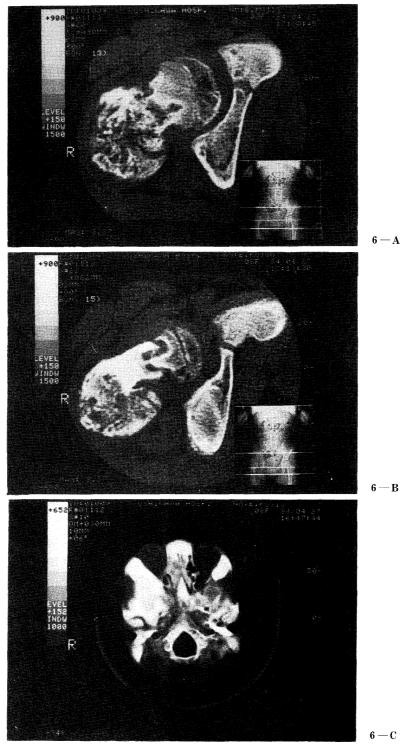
CT scan shows the fibrous change in the right femoral neck (6-A, 6-B) and sclerotic change in the right facial bone (6-C).
